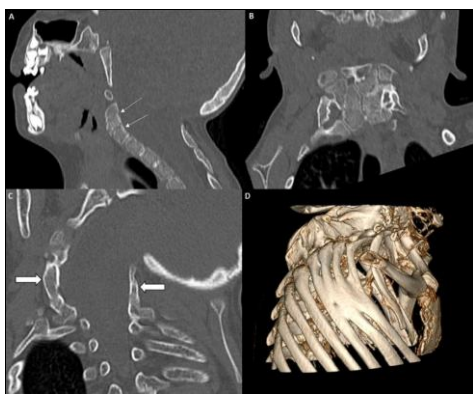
Image A is a sagittal MPR reconstruction of the CT cervical spine bone window, and Image B is a coronal MPR reconstruction CT cervical spine bone window showing fusion anomalies involving all cervical and upper dorsal vertebral bodies (marked by white line arrow). Image A also shows a capacious foramen magnum. Image C is a coronal MPR reconstruction CT cervical spine bone window showing fused bilateral cervical facet joints (marked by a white block arrow). Image D is a 3D CT volume rendering technique (VRT) sagittal view showing fused shafts of the 3rd to 6th ribs.
